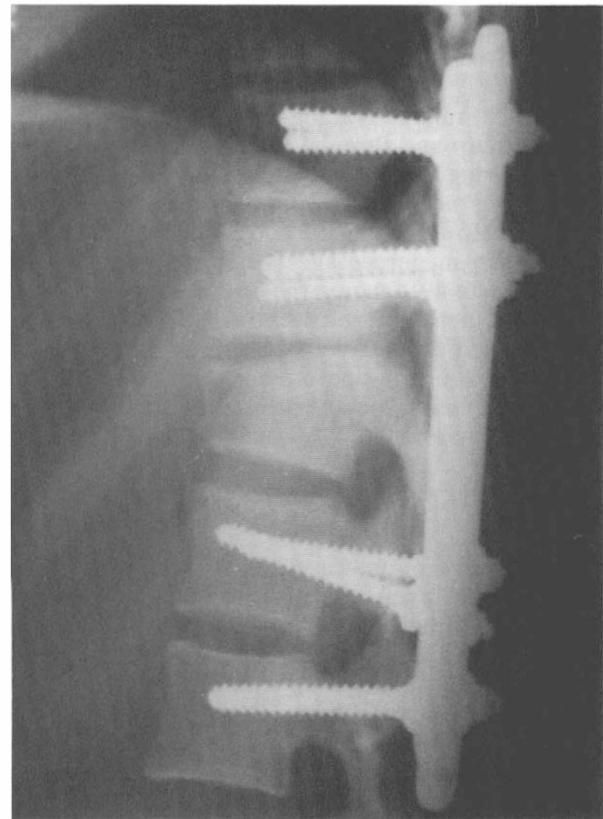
Postoperative plain radiograph of the lumbar spine demonstrates reduction of the dislocation and stability offered by a transpedicular screw-plate system
